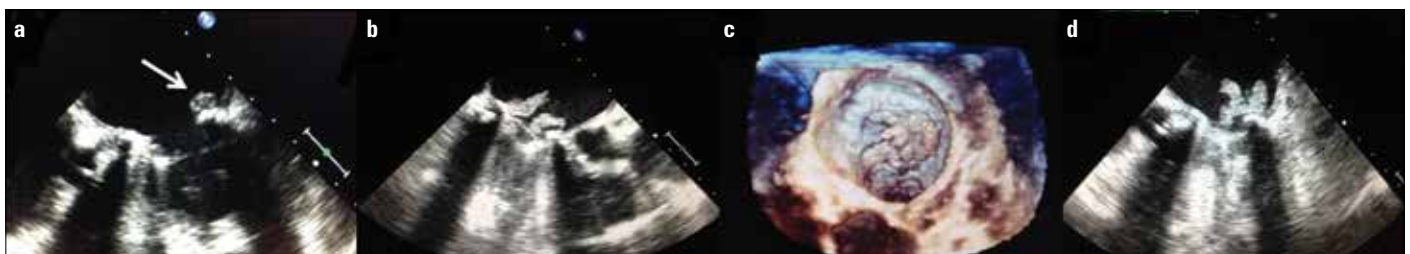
a-d. (a) White arrow shows first transesophageal echocardiographic exam at 20+. (b, d) Second transesophageal echocardiographic exam at 120+ & 20+ (c) 3-D transesophageal echocardiographic exam
